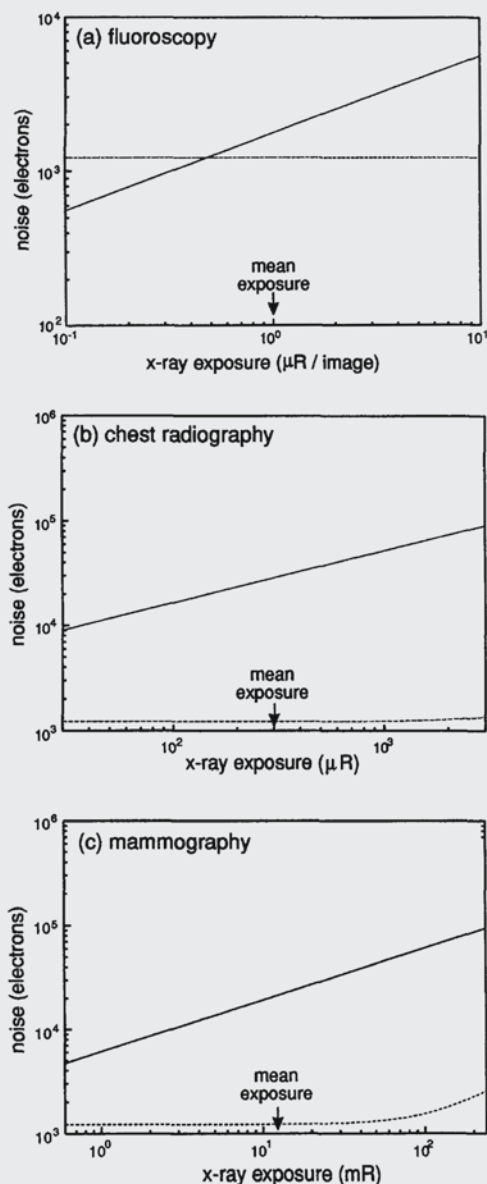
Estimation of x-ray quantum noise and electronic noise of each pixel as a function of x-ray exposure for: fluoroscopy, chest radiography, and mammography. X-ray quantum noise is plotted using solid lines, and electronic noise with dashed lines.
